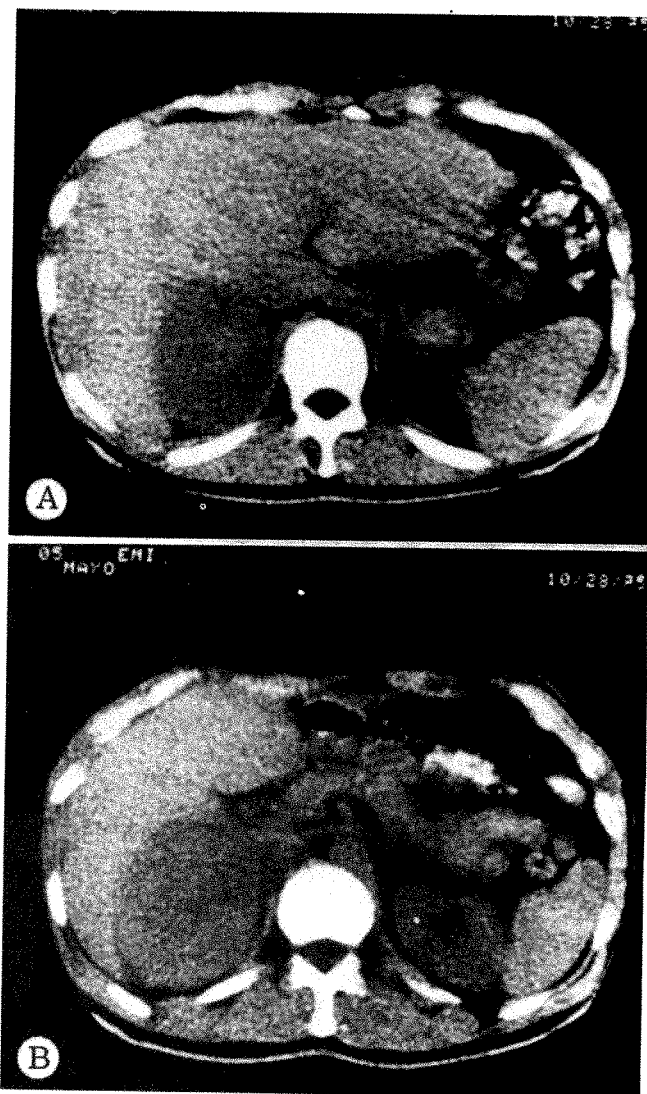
CT scans of 43-year-old man presenting with chronic relapsing febrile illness. Nuclear scan of liver showed large filling defect in posterior aspect, suggesting tumor or hepatic abscess. (Exploratory laparotomy and angiogram, performed 14 months before CT scans, were negative.) A and B, Two sections through lower portion of liver showing large, sharply circumscribed low density mass lesion posterior to right lobe. At operation, adrenal corticocarcinoma resected; regional lymphadenopathy present anterior to lower pole of large mass.
